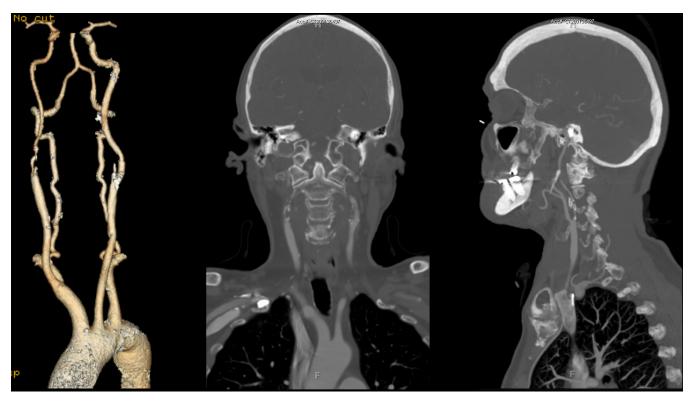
Cervical CTA with 3D reconstruction, coronal, and sagittal views of right carotid artery stenosis of 90-95%
